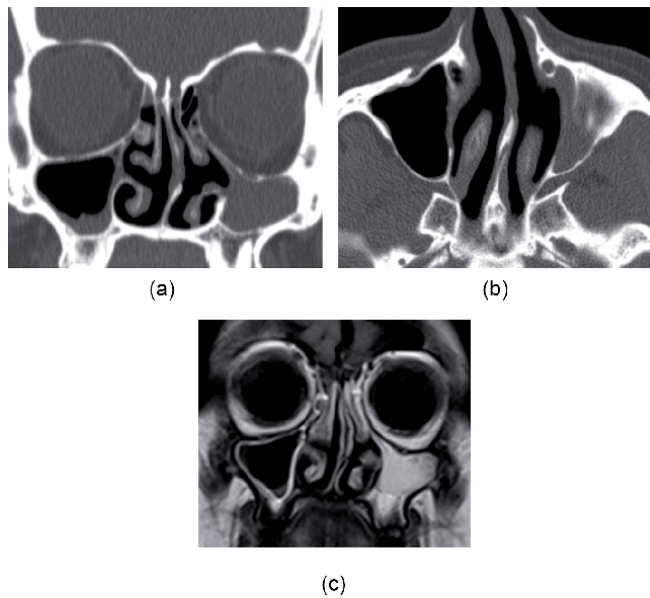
(a) Coronal CT and (b) axial CT demonstrate a left-sided hypoplastic maxillary sinus with a retracted posterior fontanelle (lateral nasal wall) that mimic chronic rhinosinusitis. (c) On coronal MRI with T2 sequence, the sinus content is equal to mucus. There is no bowing of the sinus walls as typical for mucocele.
